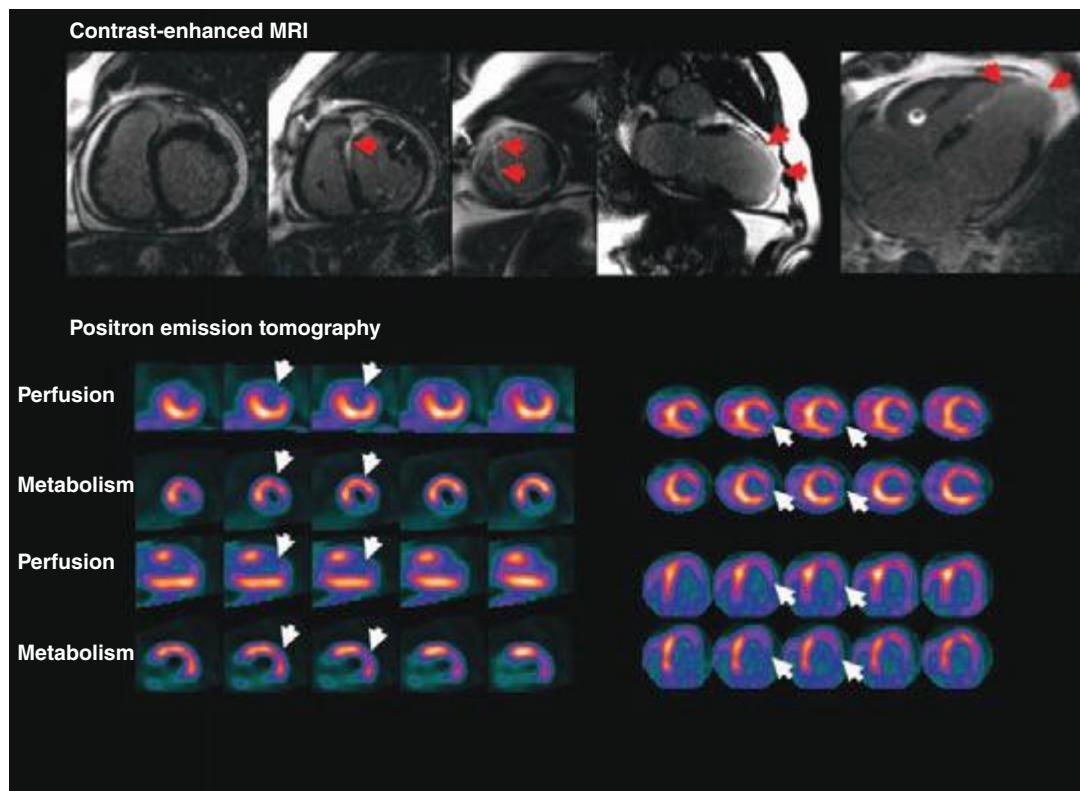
26 Examples of myocardial viability patterns obtained with cardiac magnetic resonance imaging (MRI) and positron emission tomography (PET) in three different patients with coronary artery disease. The top panel demonstrates extensive late gadolinium enhancement (bright white areas) involving the anterior, anteroseptal, and apical left ventricular walls (arrows), consistent with myocardial scar and nonviable myocardium. The lower left panel demonstrates rubidium-82 myocardial perfusion and ^{18}F -fluorodeoxyglucose (FDG) images showing a large and severe perfusion defect in the anterior, anterolateral, and apical walls, indicating preserved glucose metabolism (so-called perfusion-metabolic mismatch) consistent with viable myocardium. The right lower panel shows similar PET images demonstrating concordant reduction in perfusion and metabolism (so called perfusion-metabolic match) in the lateral wall, consistent with nonviable myocardium.
